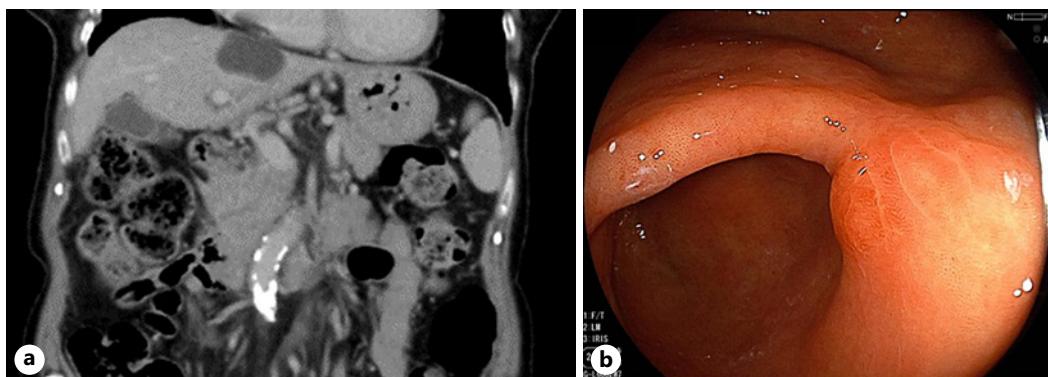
Imaging examination during 3rd treatment. a CT finding. Ascites had disappeared, and metastatic lymph nodes had shrunk and were no longer visible. b Upper gastrointestinal endoscopy showed scarring of the primary lesion.
